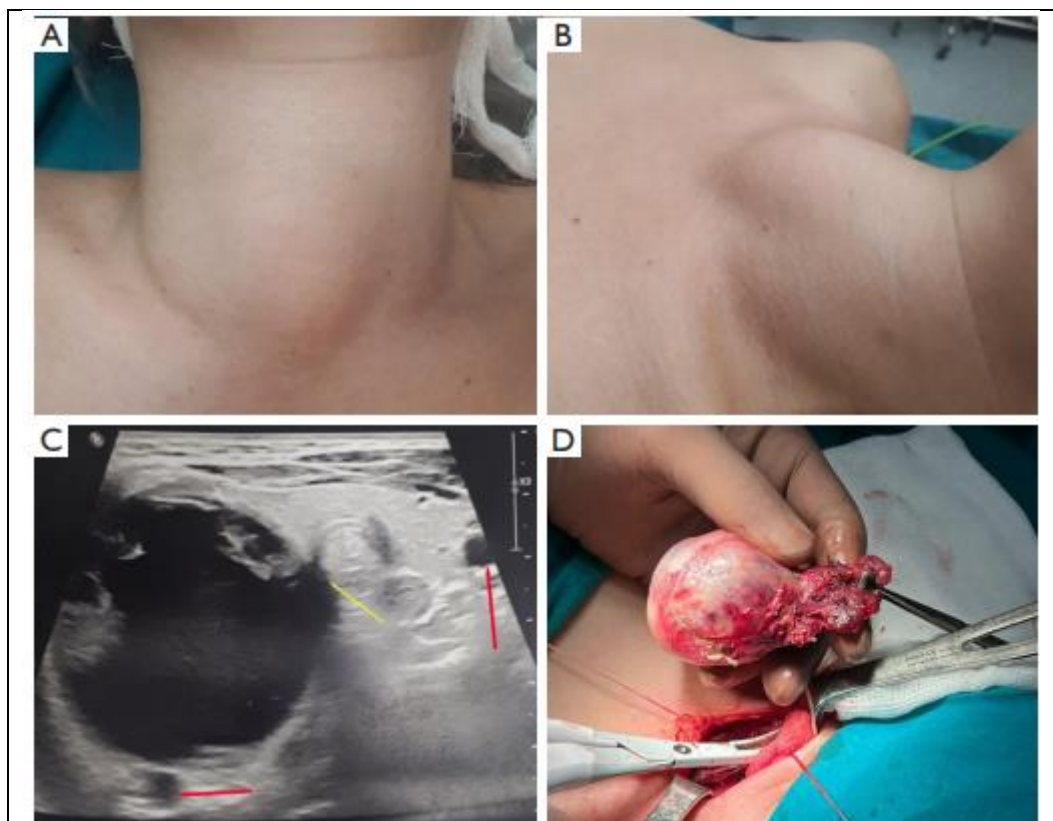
Preoperative and intraoperative images of the thyroid cyst. (A) Anterior neck mass; (B) Lateral neck mass; (C) USG of the right lobe thyroid cyst (red arrows indicate carotid artery compression; yellow arrow indicates tracheal compression); and (D) Intraoperative image of the right lobe thyroid cyst. USG, ultrasonography.
